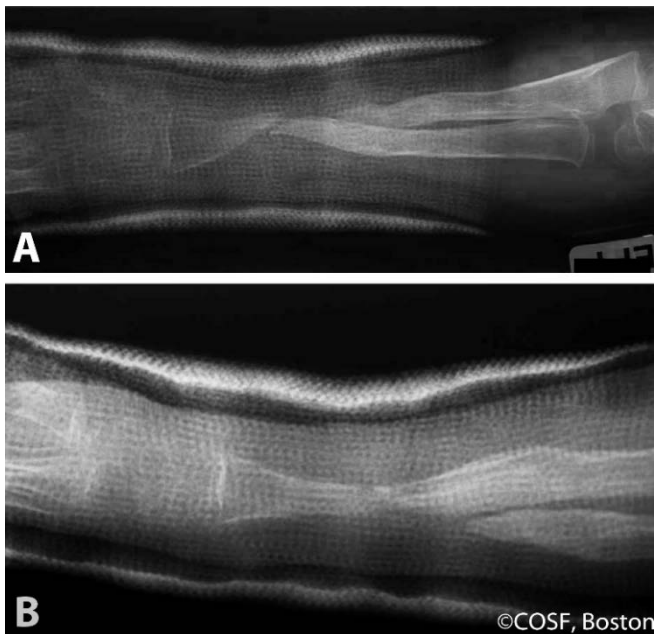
AP A and lateral B radiographs demonstrating a radius nonunion and substantial bony loss of the ulna upon presentation to referral center.
